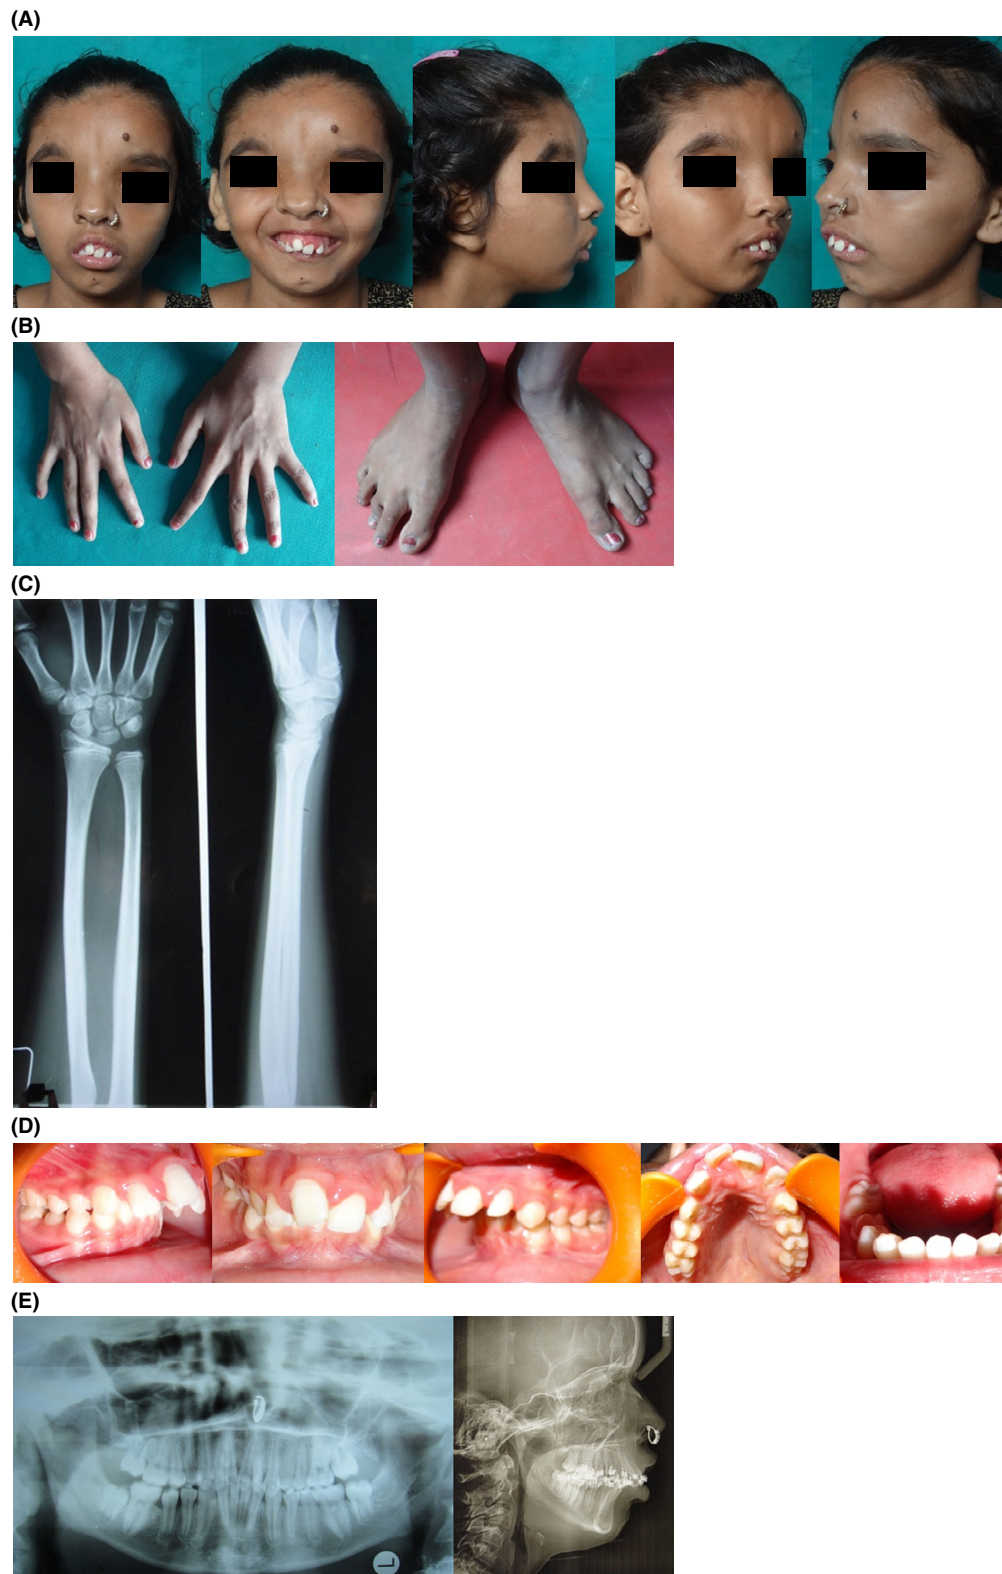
(A) Patient's extra-oral clinical photographs. (B) Patient's spidery long fingers and long toes photograph. (C) Hand wrist radiograph showing arachnodactyly. (D) Patient's intra-oral clinical photographs. (E) Panoramic X-ray and midtreatment lateral cephalogram depicting severity of mandibular retrognathia.
